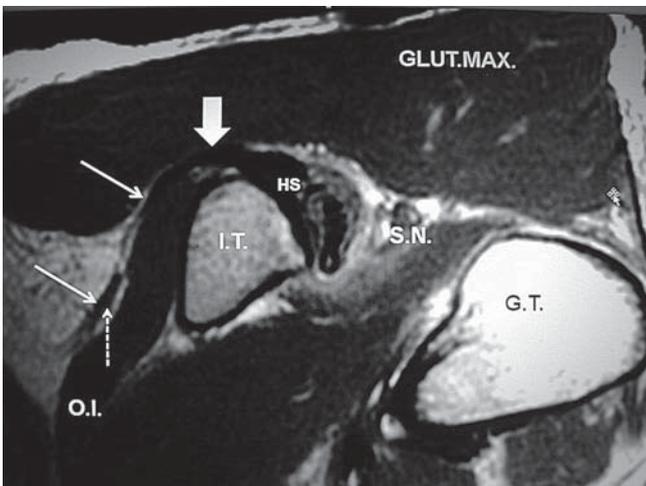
MR image at same level as Fig. 5. Long arrows indicate falciform ligament, dotted arrow the pudendal NVB.
